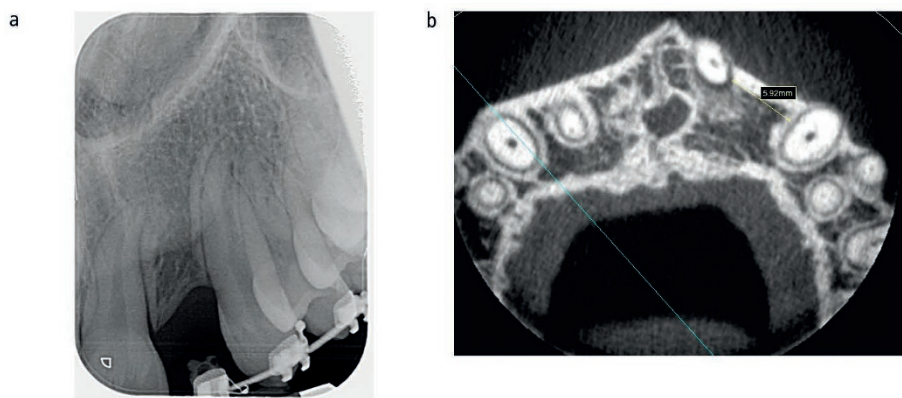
Radiograph and CBCT – revealing a lack of mesio-distal space to accommodate an implant fixture
